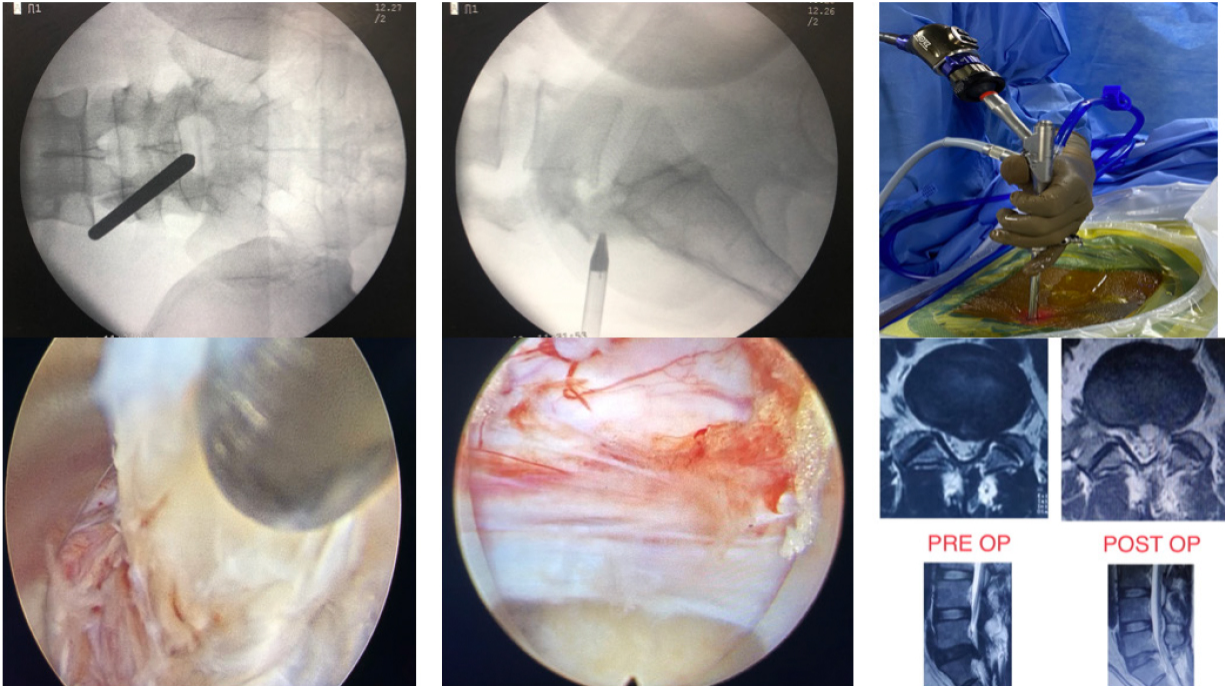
Full endoscopic discectomy: interlaminar route. (A) Dilator placement in AP view, (B) dilator placement in lateral view, (C) extruded Disc fragment removed, (D) decompressed nerve root well seen, (E) interlaminar scope and hand position, (F) pre and post-operative MRI T2WI showing removal of the fragment.
